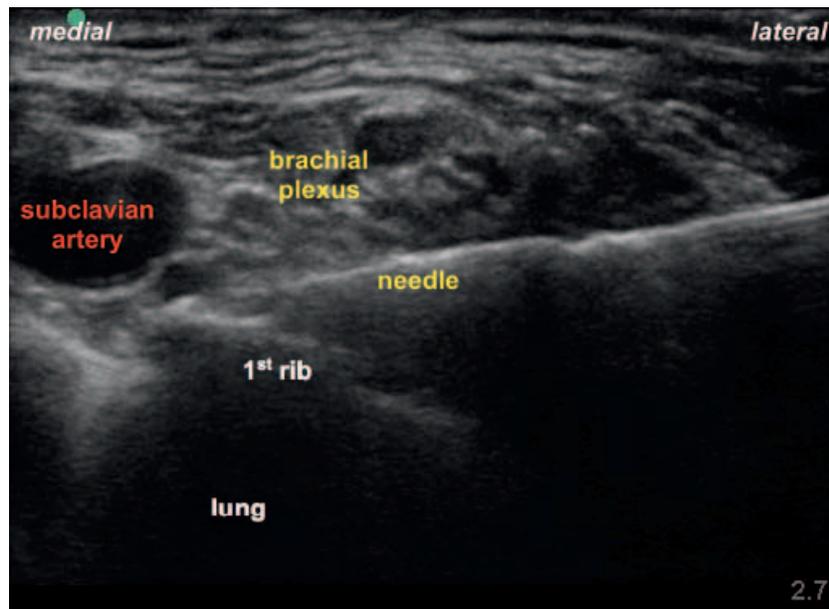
Ultrasound image demonstrating the in-plane needle approach. The needle tip is placed between the subclavian artery and first rib: “the corner pocket.”
